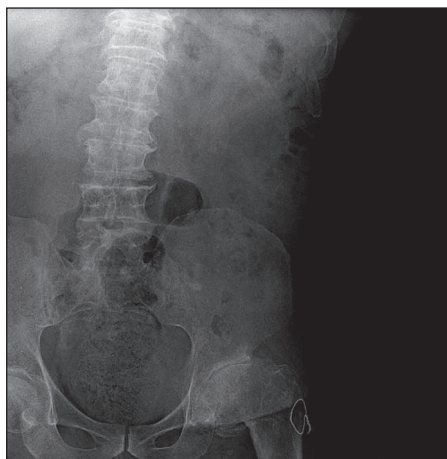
Shows conventional X-Ray of patient with left hip dysplasia and short left leg
